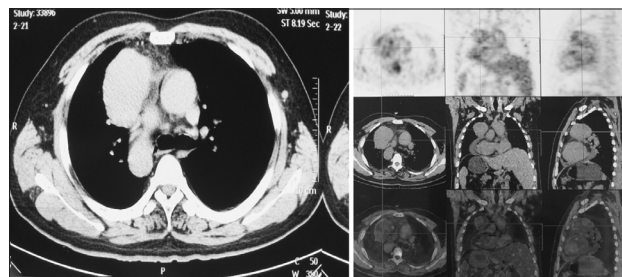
Nonenhanced computed tomography scan (left) and positron emission tomography/computed tomography scan (right) images in a patient diagnosed with thymoma complicated by situs inversus totalis.
